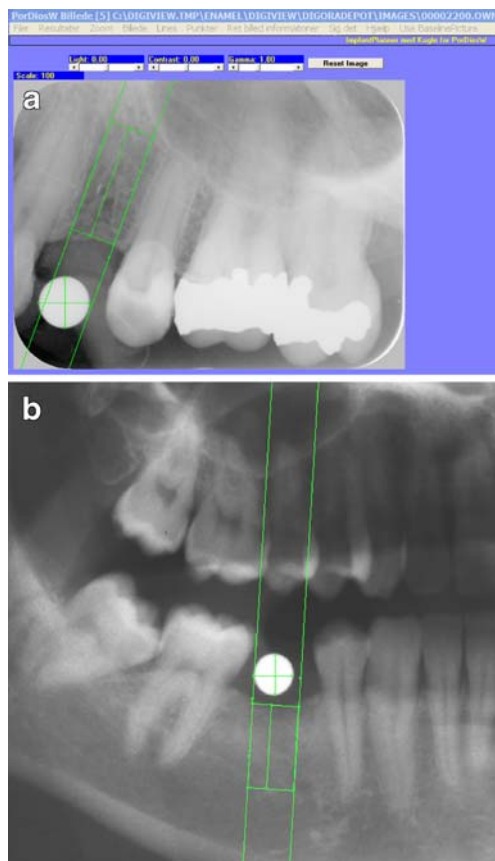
a Eight reference marks corresponding to the topmost, bottommost, leftmost, and rightmost margins of the reference metal ball, and the platform level as well as the mesial, distal, and apical demarcation of the implant-to-be set in a periapical radiograph (digitized with a resolution of 300 dpi). In this case, selection of the “appropriate” implant size was mainly dictated by the neighboring vital anatomical structures. b An example of implant planning in a panoramic radiograph (digitized with a resolution of 300 dpi), where selection of the “appropriate” implant size was mainly dictated by the size of the missing tooth rather than the neighboring anatomical structures
